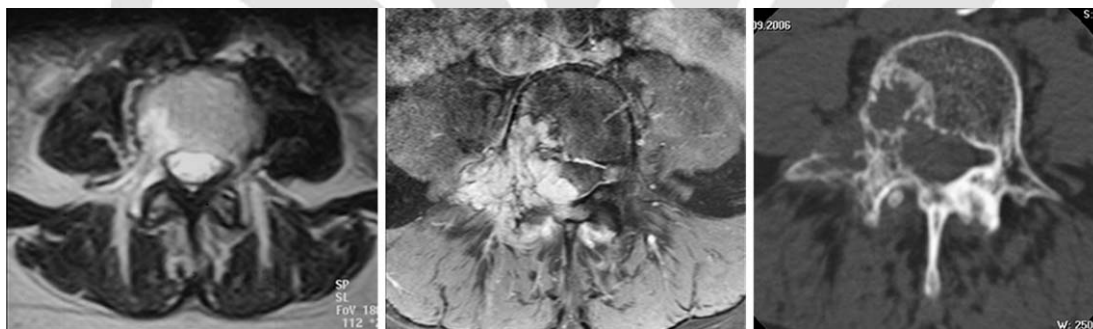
Preoperative axial MRI images of L4. Left image: hyperintense signal in T₂ within the right vertebral body and pedicle of L4 (1998). Middle image: massive enlargement of the right pedicular region, lamina and right side of the vertebral body L4 with enhancement in T₁ and compression of nerve roots L4 and L5 and the dural sac (2006). Right image: osseous destruction of right-sided marrow and corticalis of L4 with sclerosis of the adjacent bone tissue, indicating slow growth of the lesion (2006).
